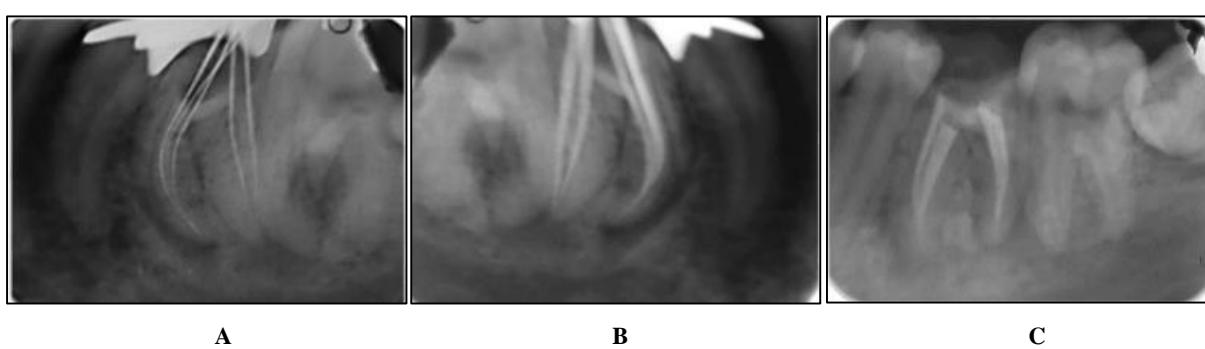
(A): Working length radiograph (MESIAL ANGULATION); (B): Master cone radiograph (C): Obturation radiograph
